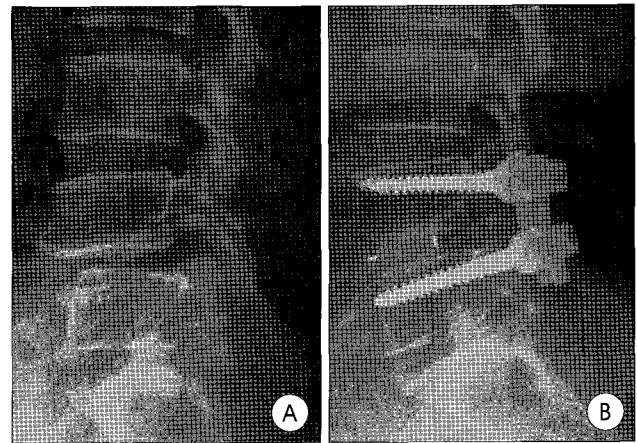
Standing lateral radiography obtained before surgery (A) and 12 months after surgery (B) showing increased segmental lumbar lordosis.
